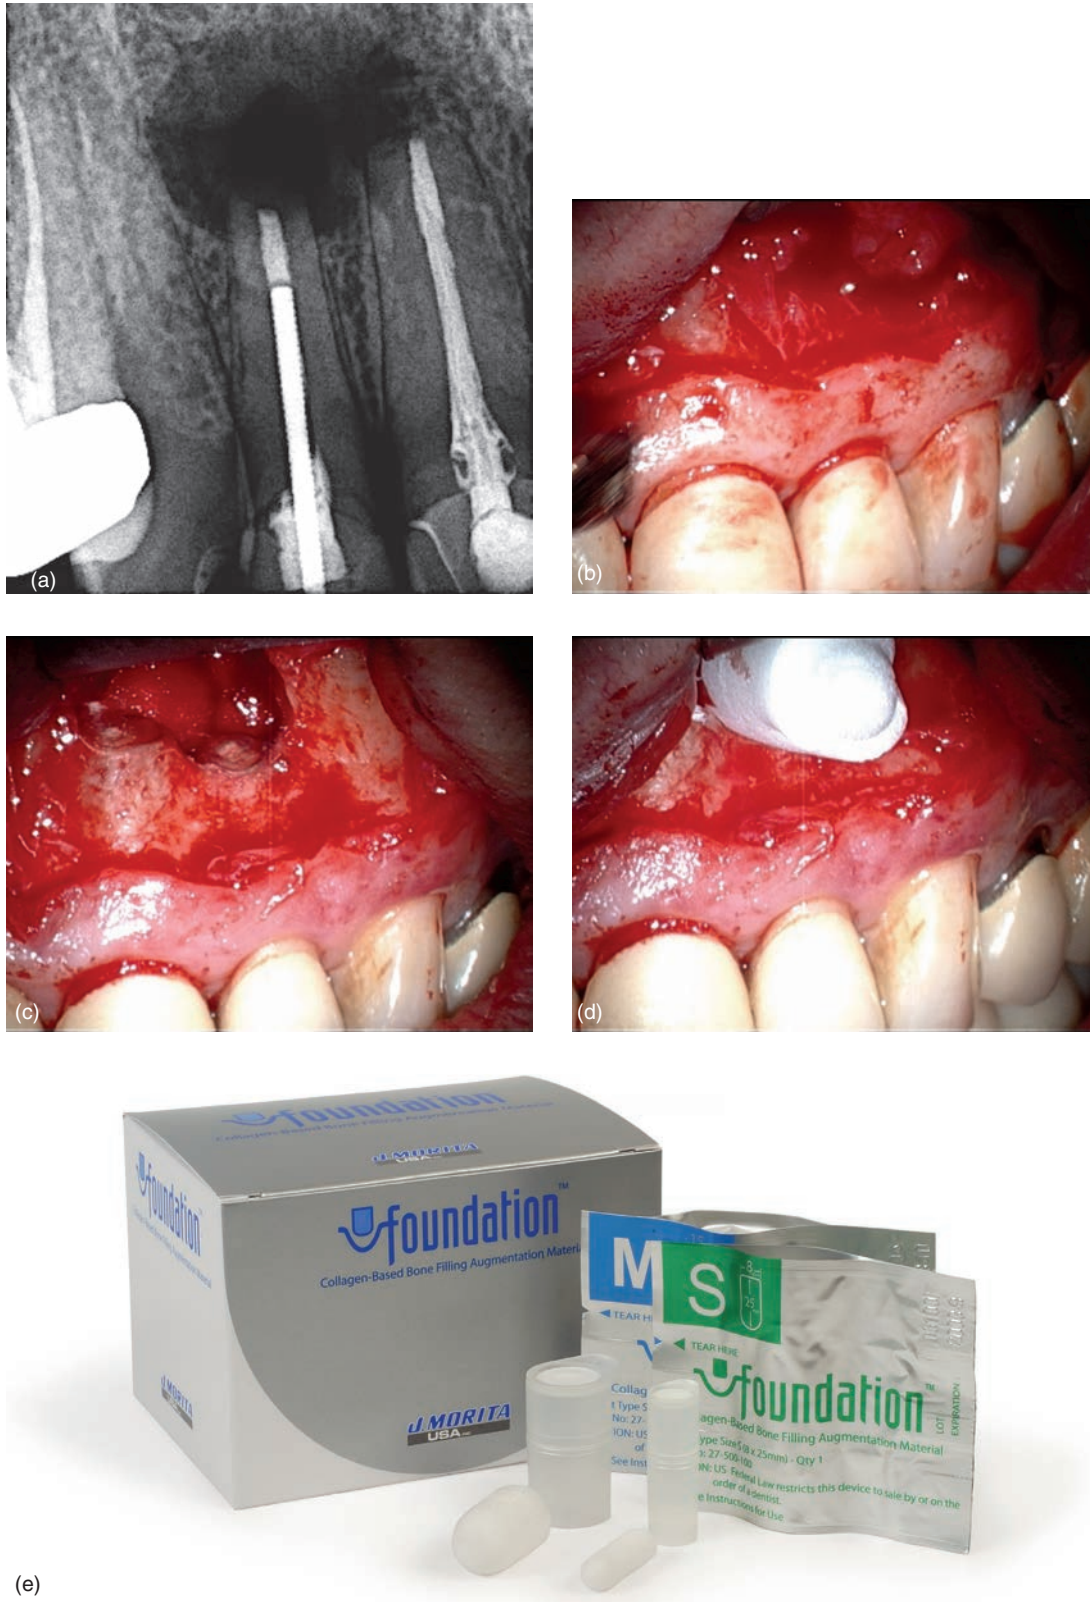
Failed apical surgery by oral surgeon on maxillary right lateral and central incisors. Treatment plan was extraction/bone graft/2 implants. Patient sought out a second opinion to try and save the teeth. (a) Preop radiograph showing large periapical lesion surrounding maxillary right lateral and central incisors; (b) incision raised and lesion is perforating facial bone; (c) Bioceramic root end fillings; (d) foundation graft material; (e) foundation graft material. (Figure 19.3d and e are courtesy of J. Morita USA, Inc.)
